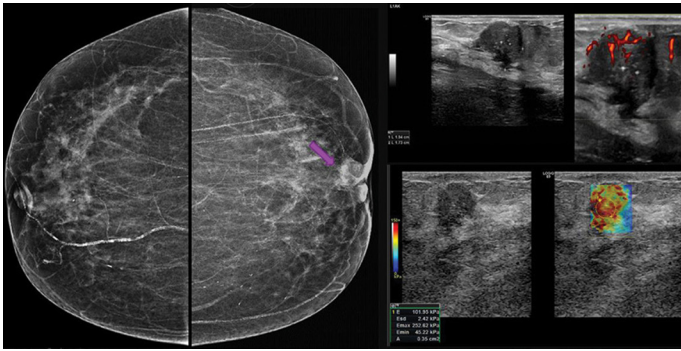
Breast carcinoma. There is an irregular suspicious mass (arrow) in the subareolar region of the left breast close to the nipple. Ultrasonography, Doppler, and elastography show an irregular, stiff, vascular lesion (red code). Core biopsy confirmed the diagnosis of breast carcinoma
